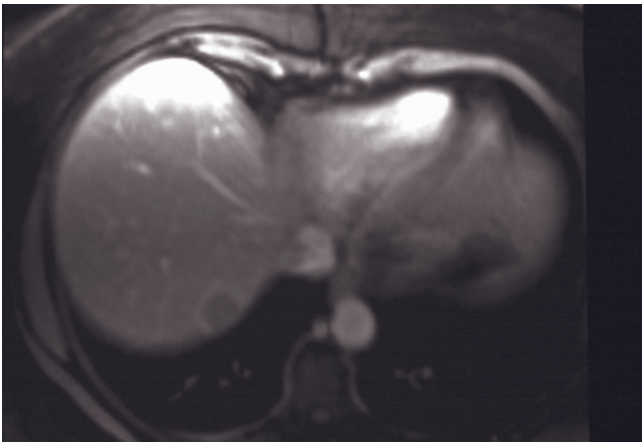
(Continued) low signal intensity on the T1-weighted image (arrow, *b*), and faint ring enhancement and perilesional enhancement on the early-phase image (*c*) that become less conspicuous on the late-phase image (*d*), consistent with a metastasis.
